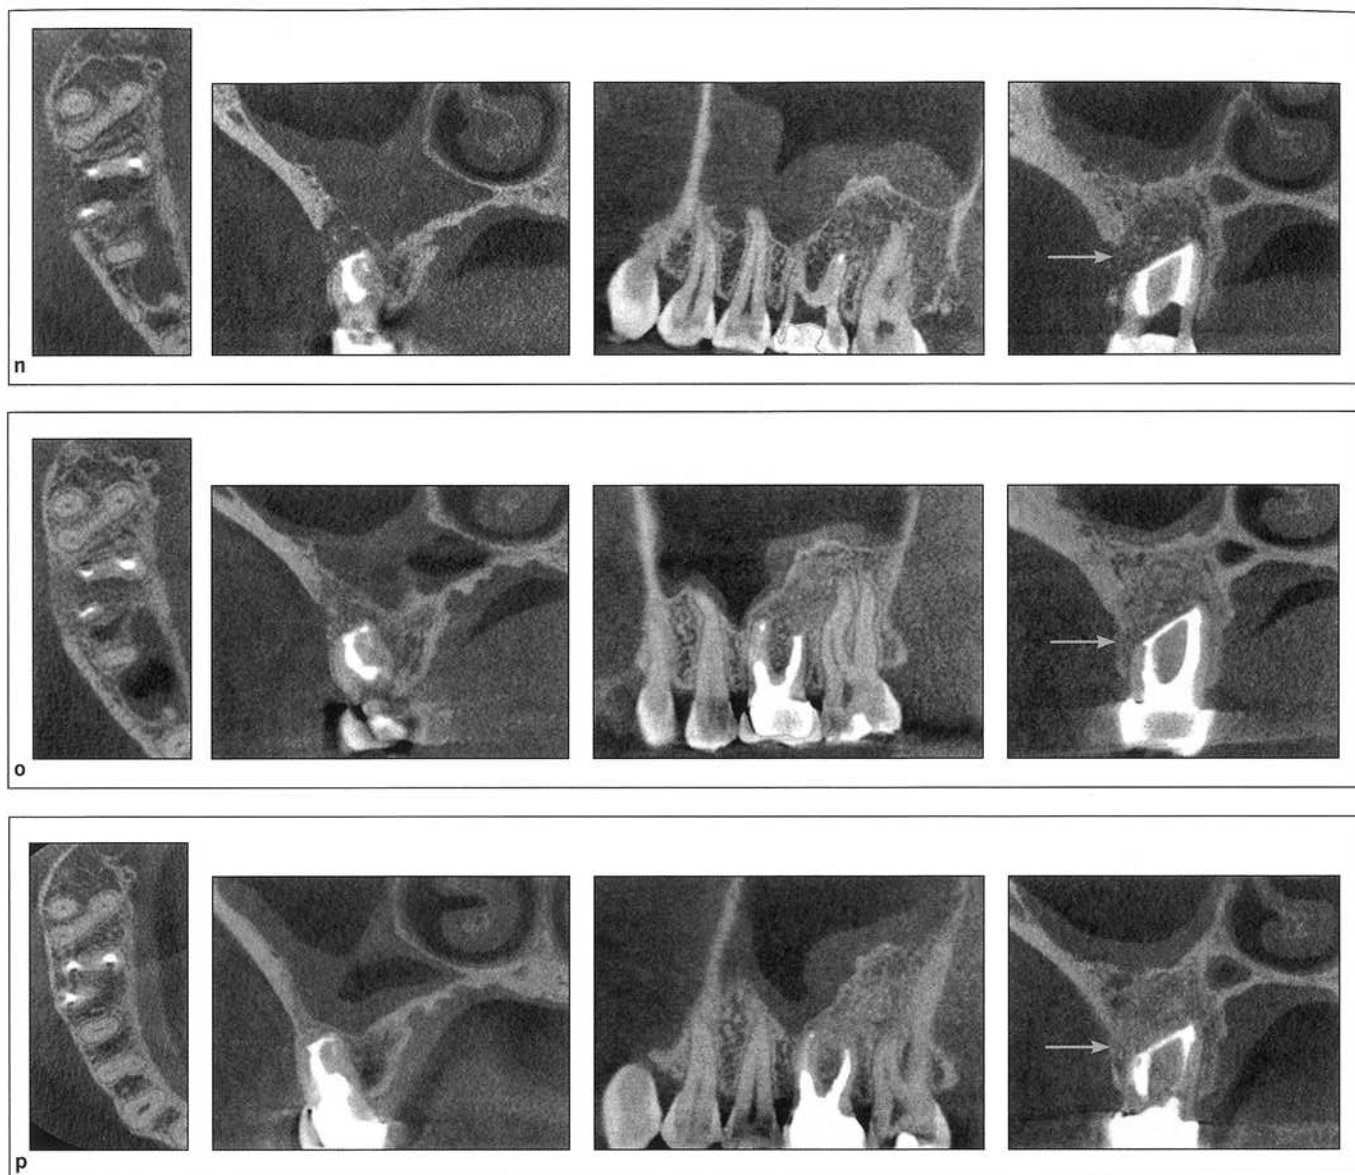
(cont) (n) Immediate postsurgical CBCT scan images. Note the buccal defect (*red and yellow arrows*). (o) Six-month recall CBCT scan images. Note the initial regeneration of the defect, including the buccal cortical plate. (p) One-year recall CBCT scan images demonstrating complete remodeling of the defect and the buccal plate (*red and yellow arrows*).
